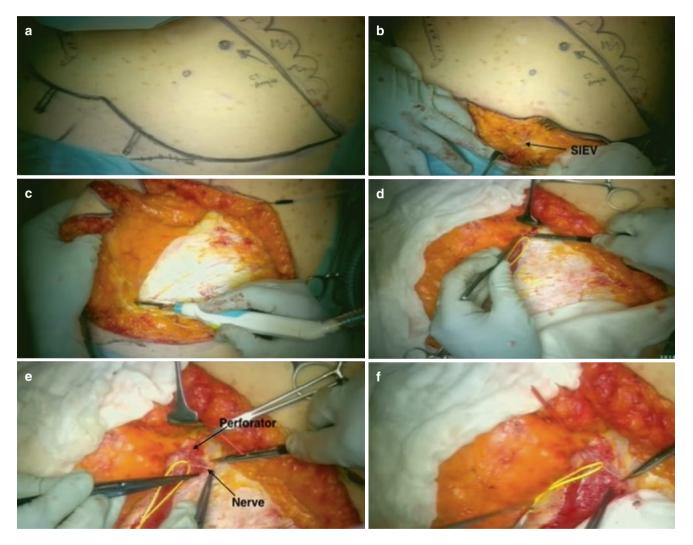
Flap harvesting sequence of the innervated DIEP. (a) Flap design including marking of dominant perforator seen in CT angiography; (b) dissection of SIEV; (c) lateral to medial standard dissection searching for the perforator and nerves; (d) identification and reference
